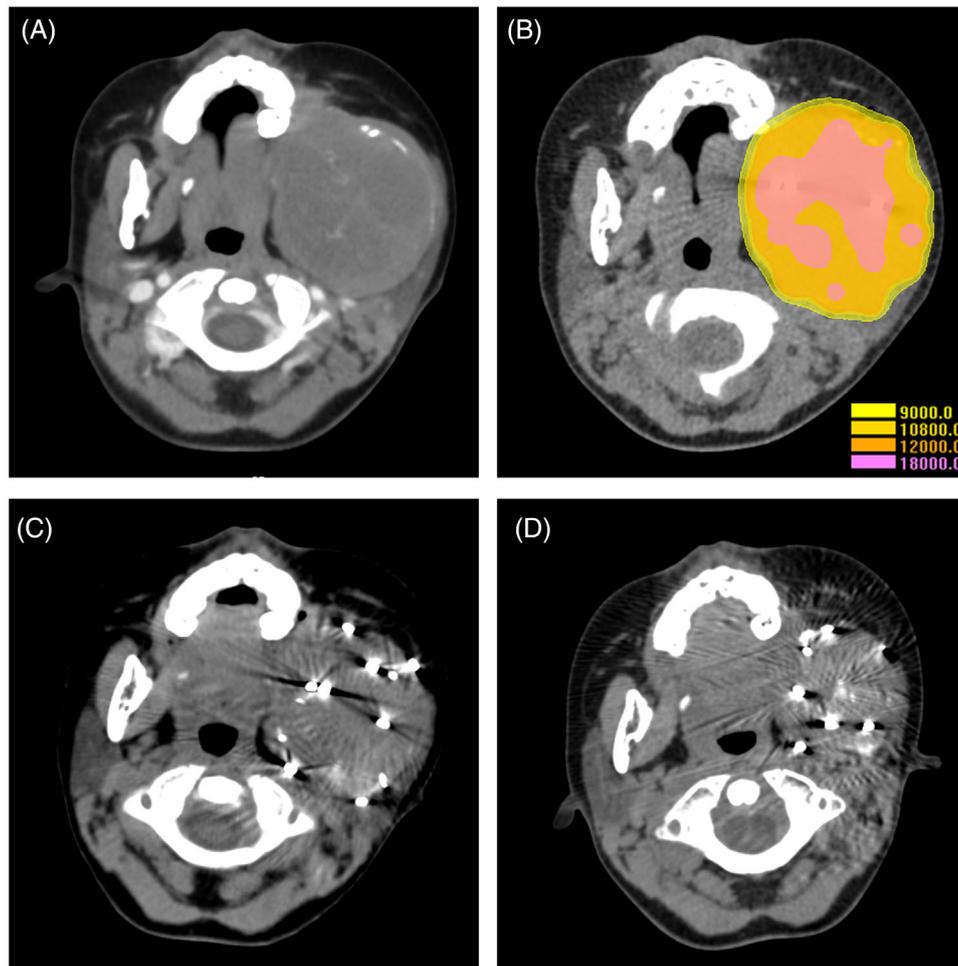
The follow-up CT image and postoperative isodose line (9000 cGy/75%, 10,800 cGy/90%, 12,000 cGy/100%, and 18,000 cGy/150%) of case with partial response. (A) Baseline, (B) 2 days after brachytherapy, (C) 2 months follow-up, and (D) 6 months follow-up
